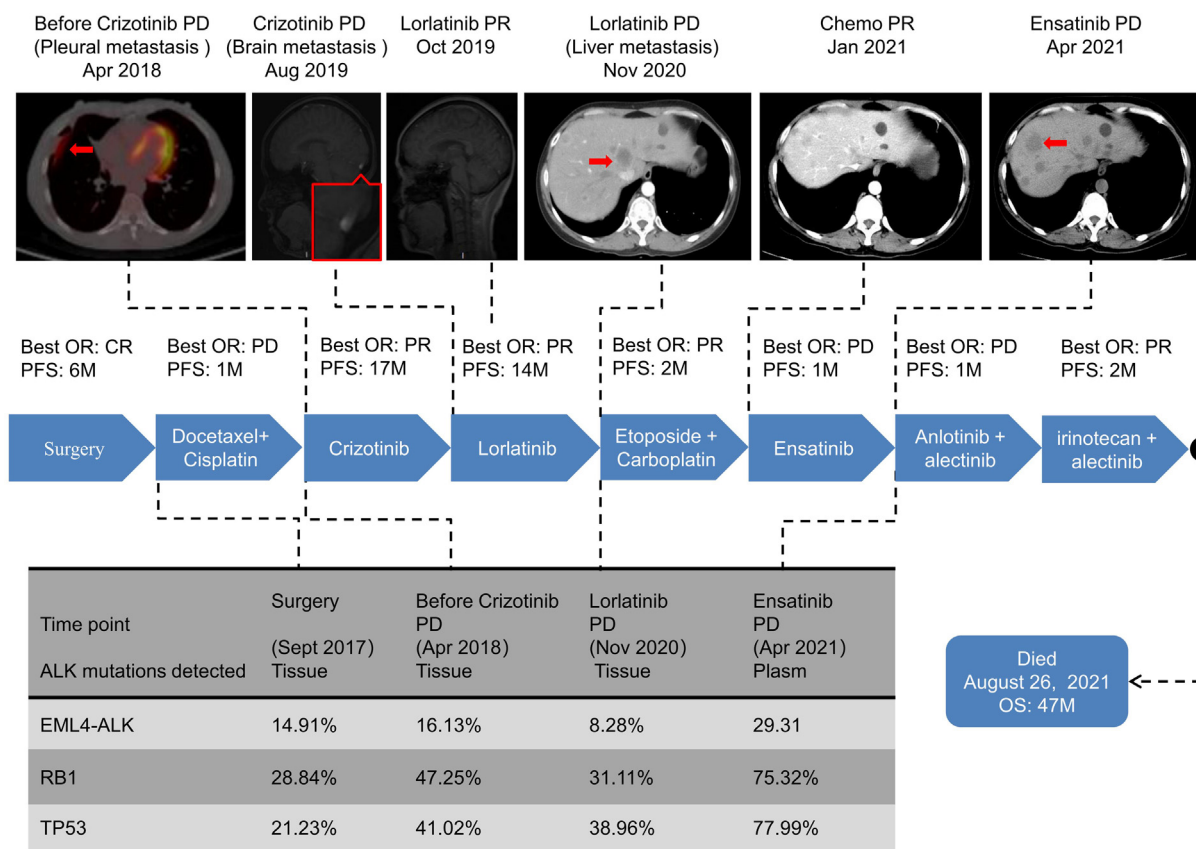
The timeline for the clinical course of the patient from diagnosis to death is found along with radiographic images and gene detection results. Apr, April; Aug, August; CR, complete response; Jan, January; M, month; Nov, November; Oct, October; OR, overall response; OS, overall survival; PD, progression of disease; PFS, progression-free survival; PR, partial response.
